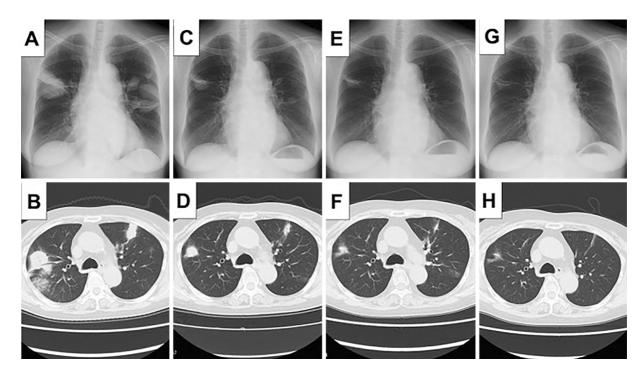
The patient's chest radiography and computed tomography (CT) findings. (A) Chest radiography and (B) chest CT findings on admission; (C) chest radiography and (D) chest CT after three weeks of treatment with ampicillin/sulbactam (AMPC/SBT); (E) chest radiography and (F) chest CT after three weeks of treatment with sulfamethoxazole/trimethoprim (ST); (G) chest radiography and (H) chest CT after nine weeks of treatment with ST. Multiple masses and nodules are seen predominantly in the upper lung fields and upper lobes, respectively, demonstrating a rim of ground-glass opacities on admission (A, B). After three weeks of treatment with AMPC/SBT, the masses and nodules had shrunk (C, D). The size of the nodules and masses reduced progressively, as seen via imaging examinations performed at three (E, F) and nine (G, H) weeks after ST initiation.
